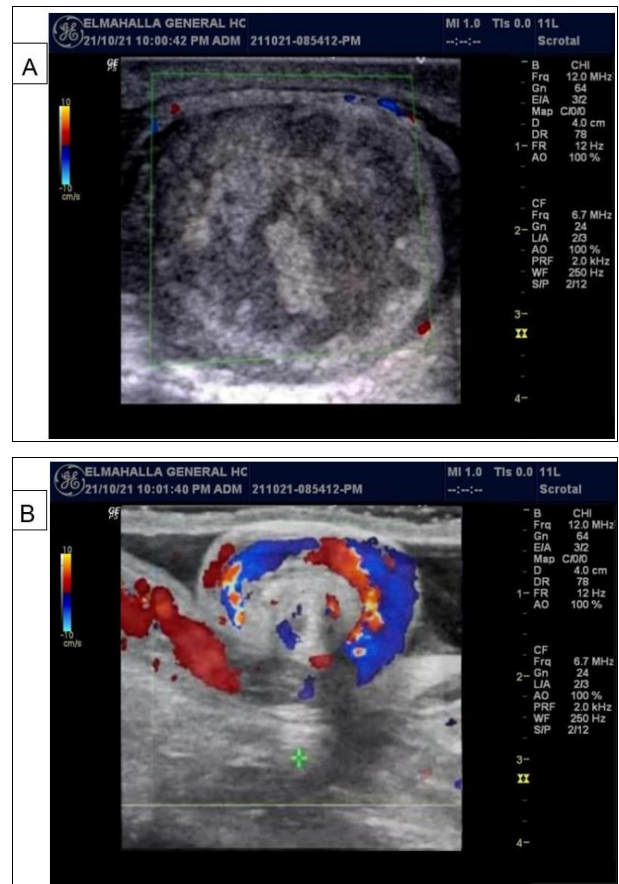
A&B: scrotal ultrasound revealed
